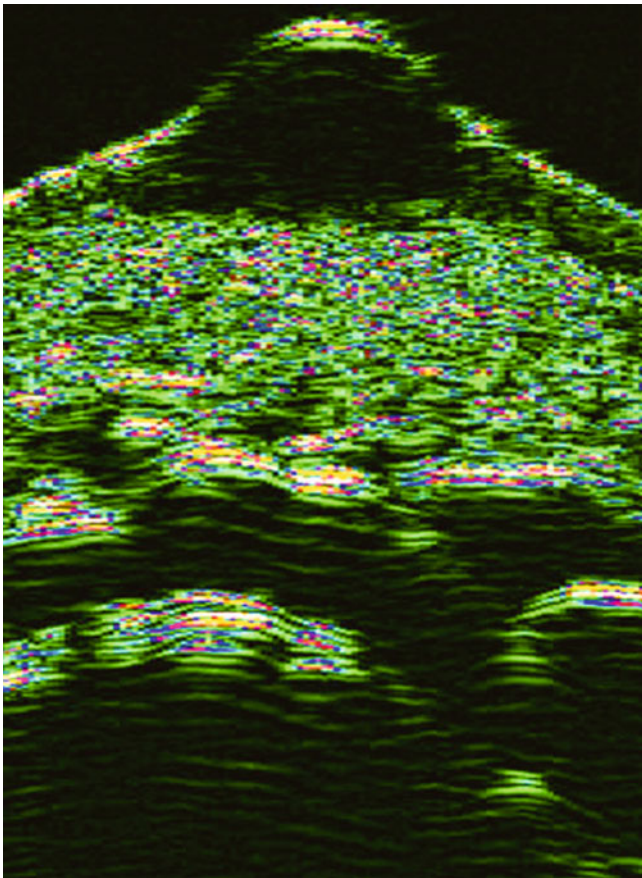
20 MHz ultrasound image of a melanoma on the lower extremity using water as a conductor medium
